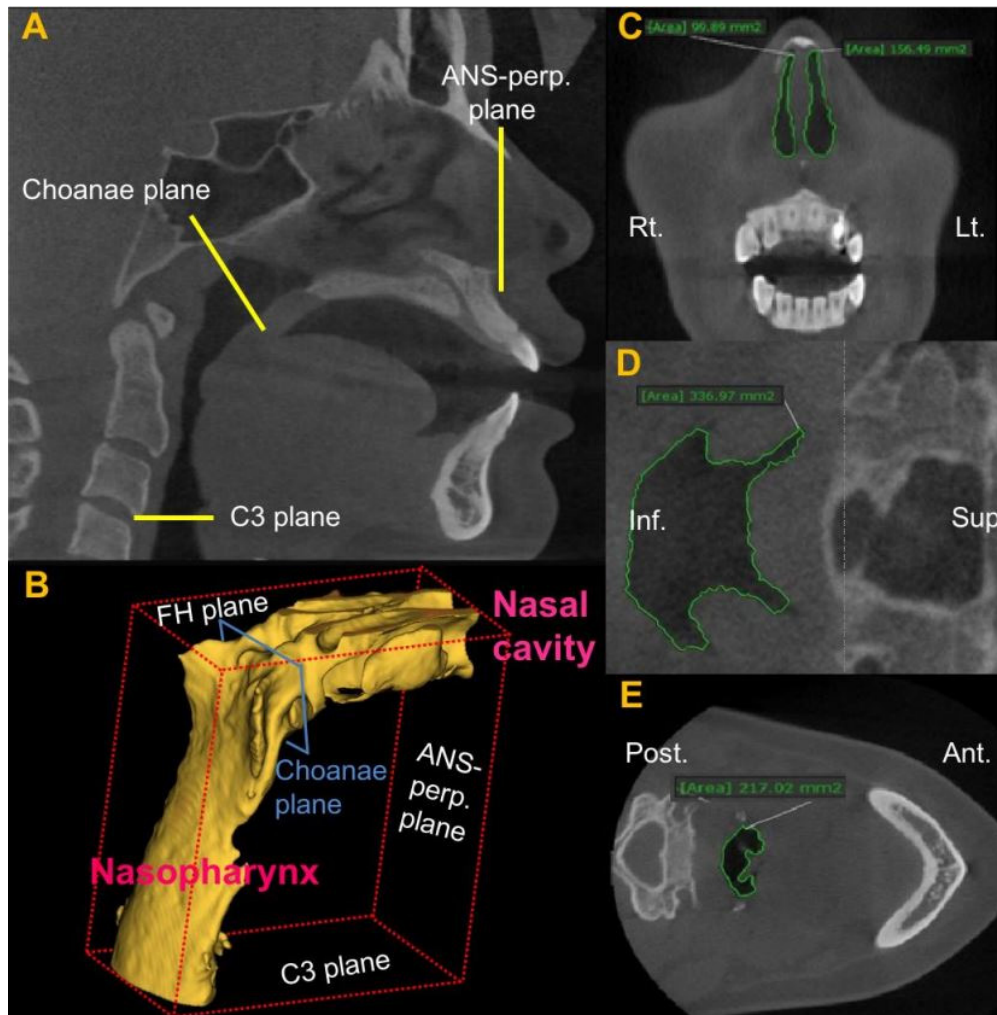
Measurements of the volume and cross-sectional area of the nasal airway using cone beam computed tomography in patients who underwent miniscrew-assisted rapid palatal expansion
